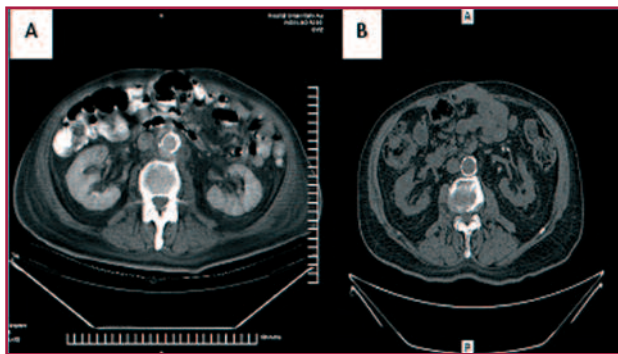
A. Computed tomography scan without contrast showing mycotic aneurysm. B. Control computed tomography scan with stent (year 2012)
